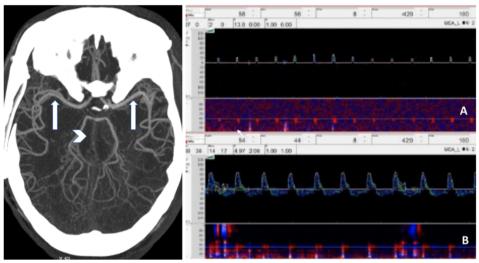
TCD arterial collapse visible on CTA (*left*) was verified by the presence of systolic spikes (A) or nonprogressive oscillatory flow (B) in the MCAs (*arrows*) and basilar artery (*arrowhead*). Figure is available in color online only.
